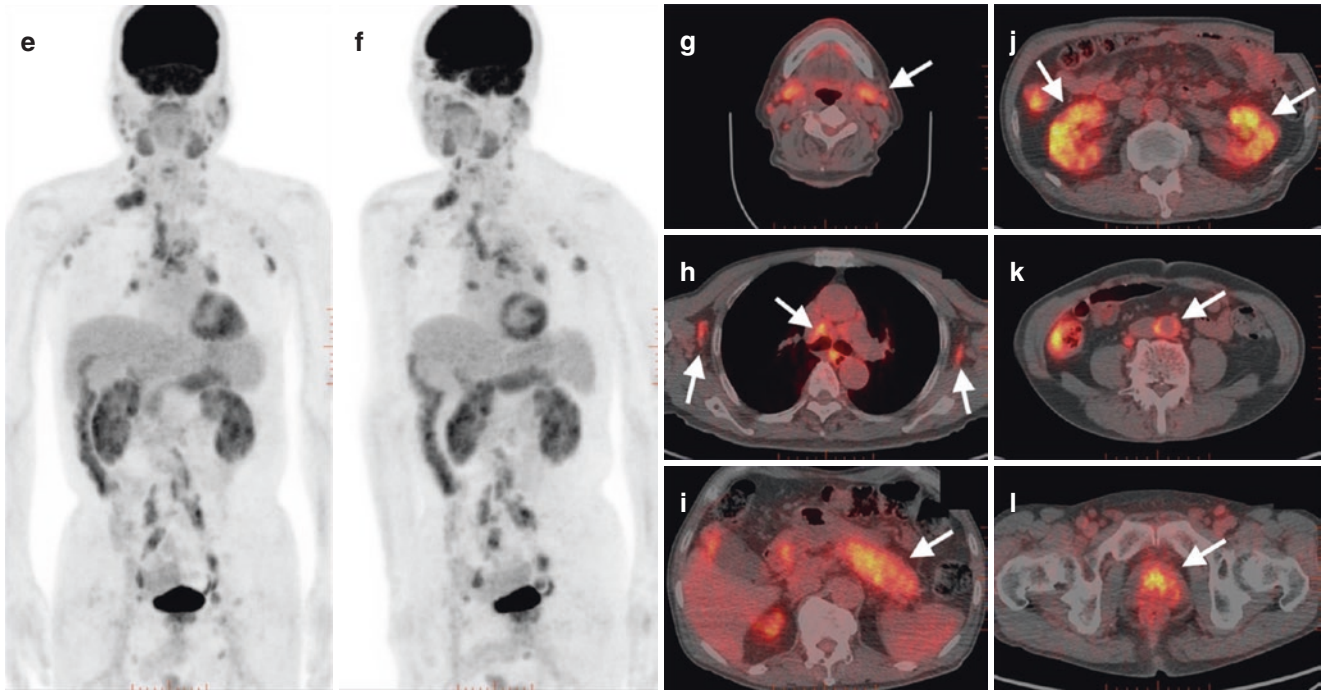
Case 2 ¹⁸F-FDG PET/CT
